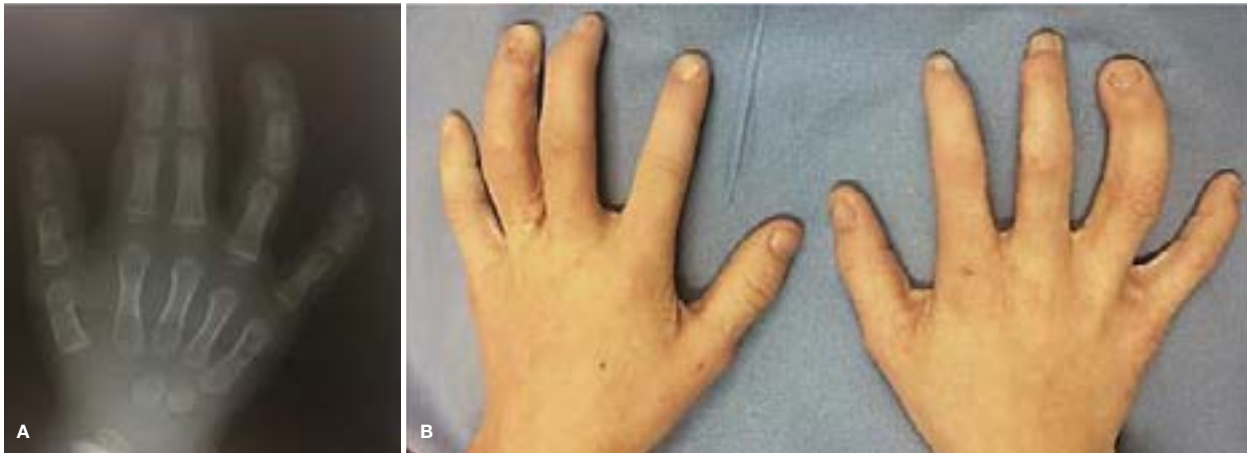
Preoperative radiograph (A) of right hand exhibiting syndactyly. Soft tissue union of the right index and middle finger. Clinical picture (B) of hands after surgical correction.
